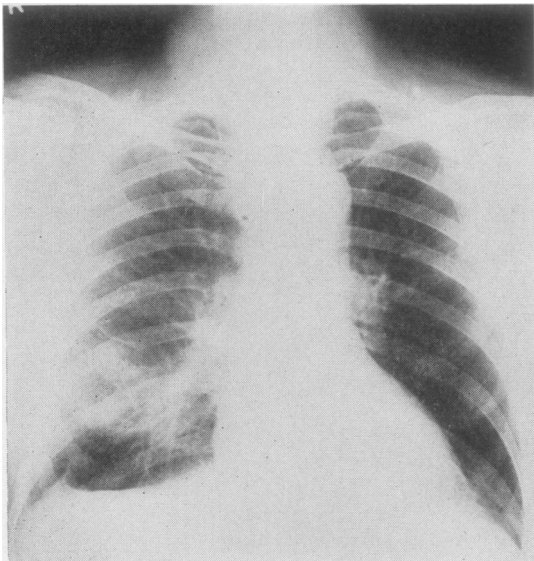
H.W.: Radiograph taken on February 8, 1957, at the time of right-sided pleurisy.
